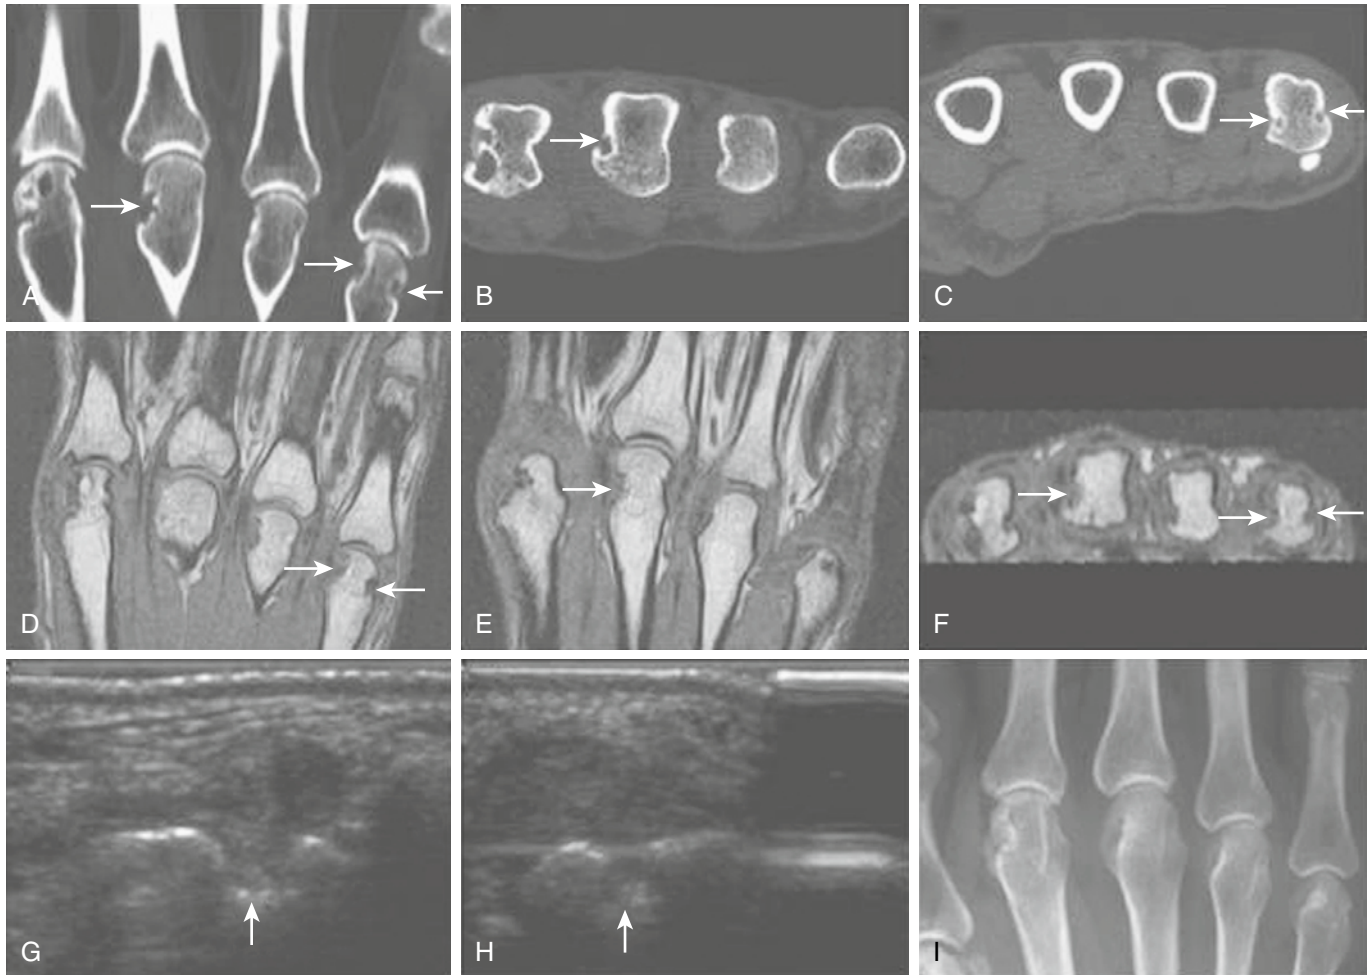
IMAGING OF THE METACARPOPHALANGEAL (MCP) JOINT. Comparison of computed tomography (CT), magnetic resonance imaging (MRI), ultrasonography and radiography of the 2nd to 5th (MCP) joints in a rheumatoid arthritis patient. CT of the 2nd to 5th MCP joints, in coronal (A) and axial (B, C) planes. Erosions in the 3rd and 5th metacarpal heads are marked with arrows. T1-weighted MRI of the 2nd to 5th MCP joints, in the coronal (D, E) and axial (F) planes reveal the same erosions in the 3rd and 5th metacarpal heads as marked on the CT images. Ultrasound image at the ulnar aspect of the 5th metacarpal head, in longitudinal (G) and transverse (H) planes. An erosion (white arrow) at the same site as detected by CT and MRI (white arrows in A, C, D, and F) is documented in both planes. Radiography (I) reveals no erosions at the corresponding sites. (From Døhn UM, Ejbjerg BJ, Court-Payen M, et al: Are bone erosions detected by magnetic resonance imaging and ultrasonography true erosions? A comparison with computed tomography in rheumatoid arthritis metacarpophalangeal joints. *Arthritis Res Ther* 2006;8:R110.)
